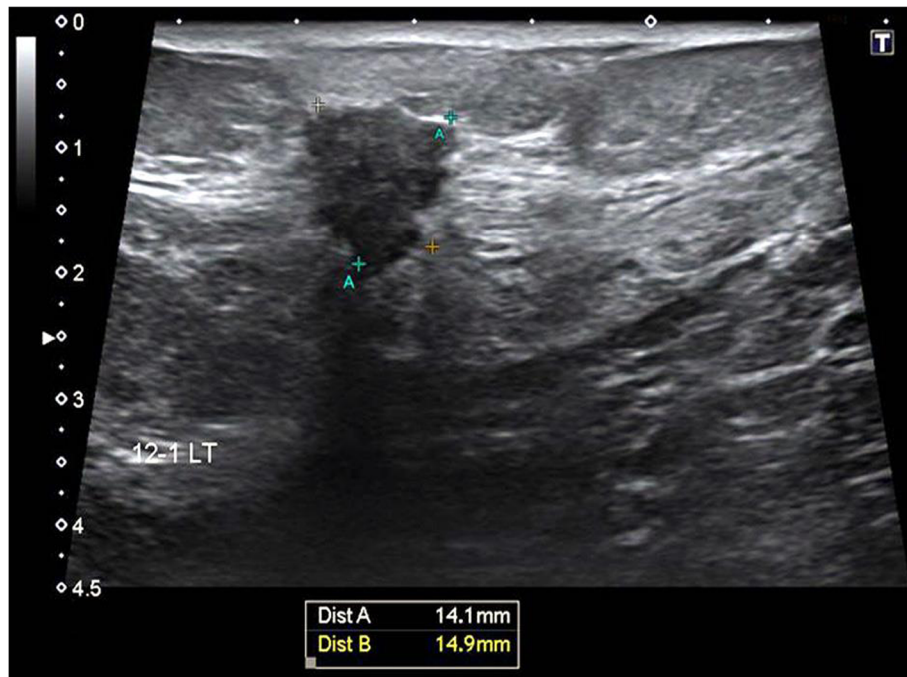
B-mode ultrasound showed irregular hypoechoic speculated mass with antiparallel orientation and posterior shadowing measuring about (14.1 × 14.9 mm), assessed as BIRADS 5. Pathology: true cut biopsy revealed infiltrating duct carcinoma grade III. Biological markers: ER positive, PR positive, HER/neu-2 negative, and Ki67 positive
